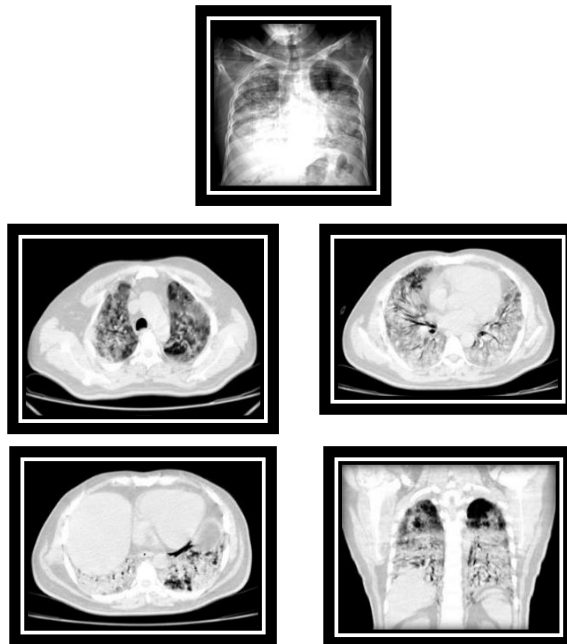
58 year old male, who had fever for 20 days with progressive coughing and shortness of breath. Saturation at admission was 50 %. X – ray finding “ PA chest x- ray shows bilateral consolidation mainly involving the lower lobes with peripheral predominance in the upper lobes. CT finding “Bilateral consolidations of both lung fields with small areas of GGO mainly seen in the upper lobes the air bronchogram noted, reactive lymph nodes, no pleural effusion.85% of the lungs are involved. CO-RADS 5 high likely COVID-19 with RT – PCR positive .
